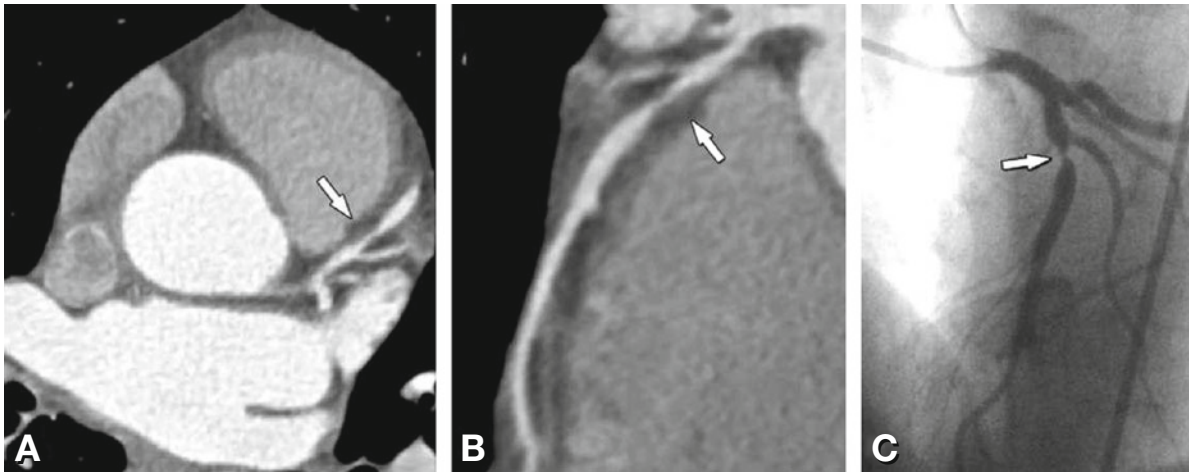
Acute presentation of a 43-year-old man with progressive angina pectoris (without elevated troponin). Coronary CT angiography shows an outwardly (positively) remodeled, noncalcified, stenotic lesion (arrow) in the left anterior descending coronary artery (Panel A, axial image; Panel B, curved multiplanar reformation), confirmed on conventional coronary angiography (Panel C)
